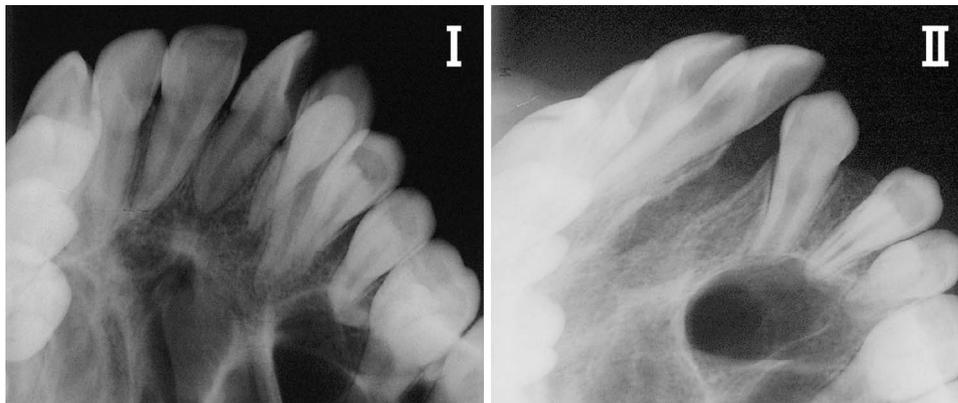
Bergland grading scale used in the radiographic assessment of bone-grafted alveolar clefts. Type I = septal height approximately normal. Type II = septal height at least three-quarters of normal.
